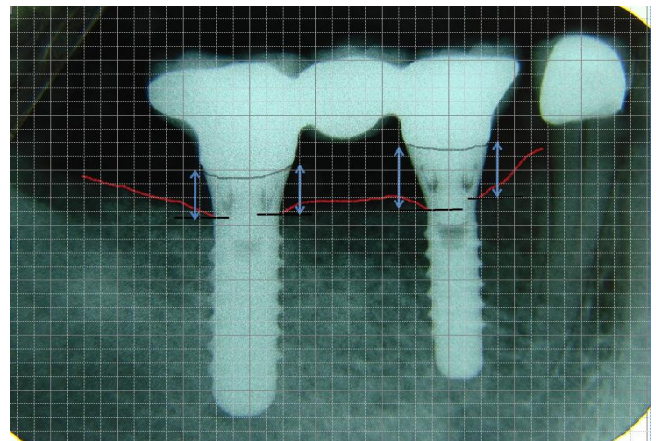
Periapical radiographs were obtained by using a paralleling device and linear distance measurements were made.
